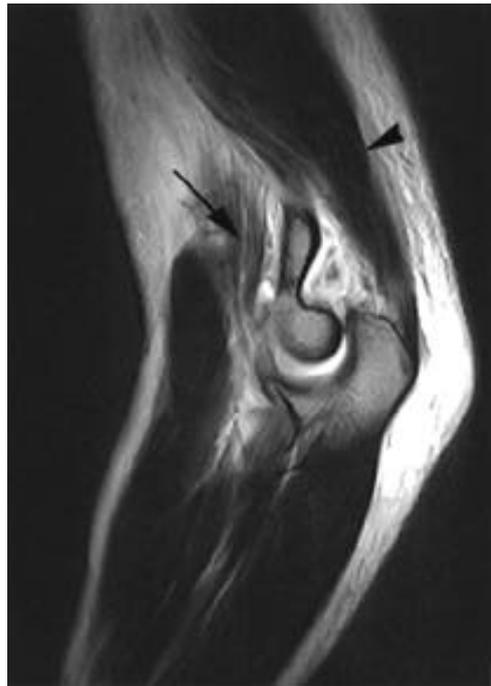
T2-weighted sagittal MRI reveals that partial tear of the brachialis muscle (arrow), well preserved triceps muscle (arrow head), and diffuse edema of the soft tissue in posterior part of the elbow.
